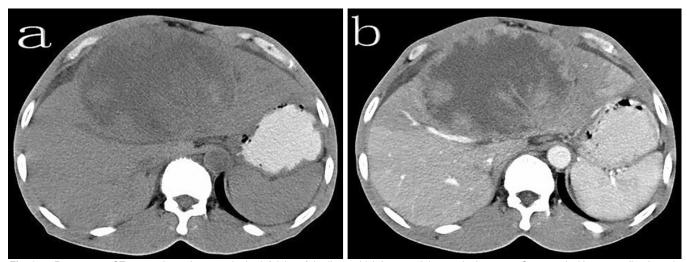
a. Pre-contrast CT scans showed a mass in the left lobe of the liver, which has a subtle marginal contour. Compared with surrounding hepatic tissue, the mass was hypodense. b. After the contrast injection, the mass was slightly enhanced, especially on the edge. Its density of central area was as same as before that, being lower than the surrounding tissue.
